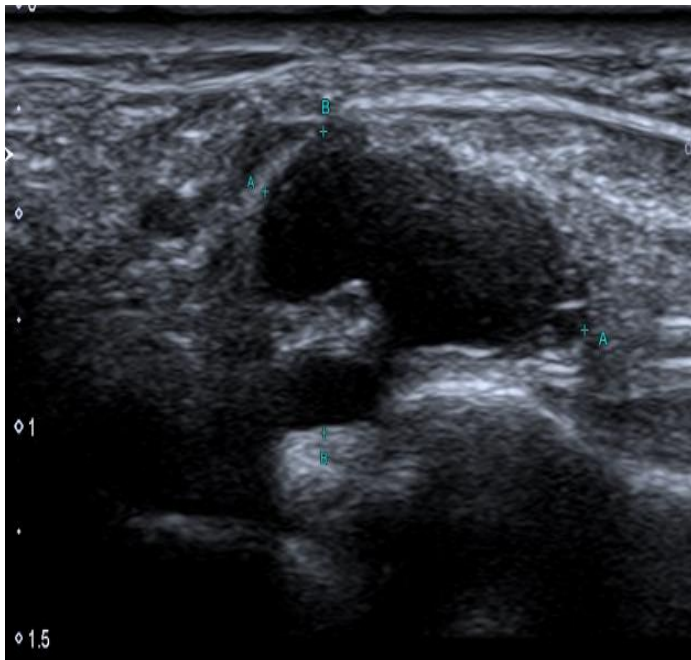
and 6): A 27 years old female patient complaining from volar wrist pain and swelling. Figure 5 shows Ultrasound images show radio-scaphoid ganglion cyst with internal echoes. Figure 6 shows MRI images that show the same findings.
